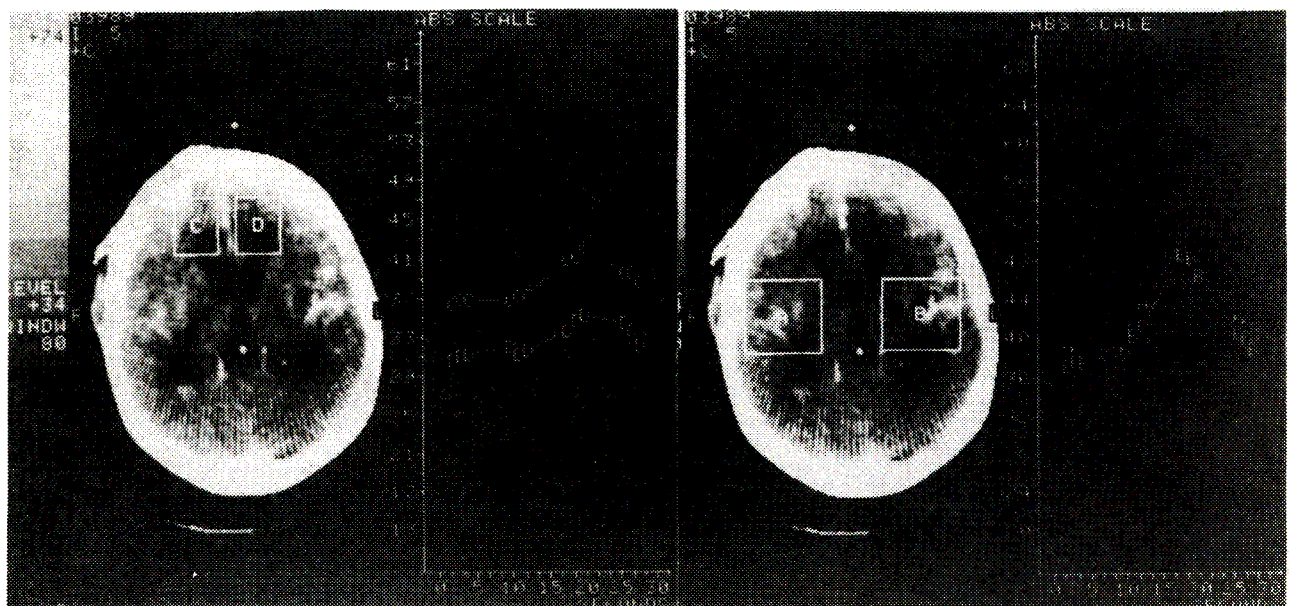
(a,b). Dynamic CT post-operatively.
